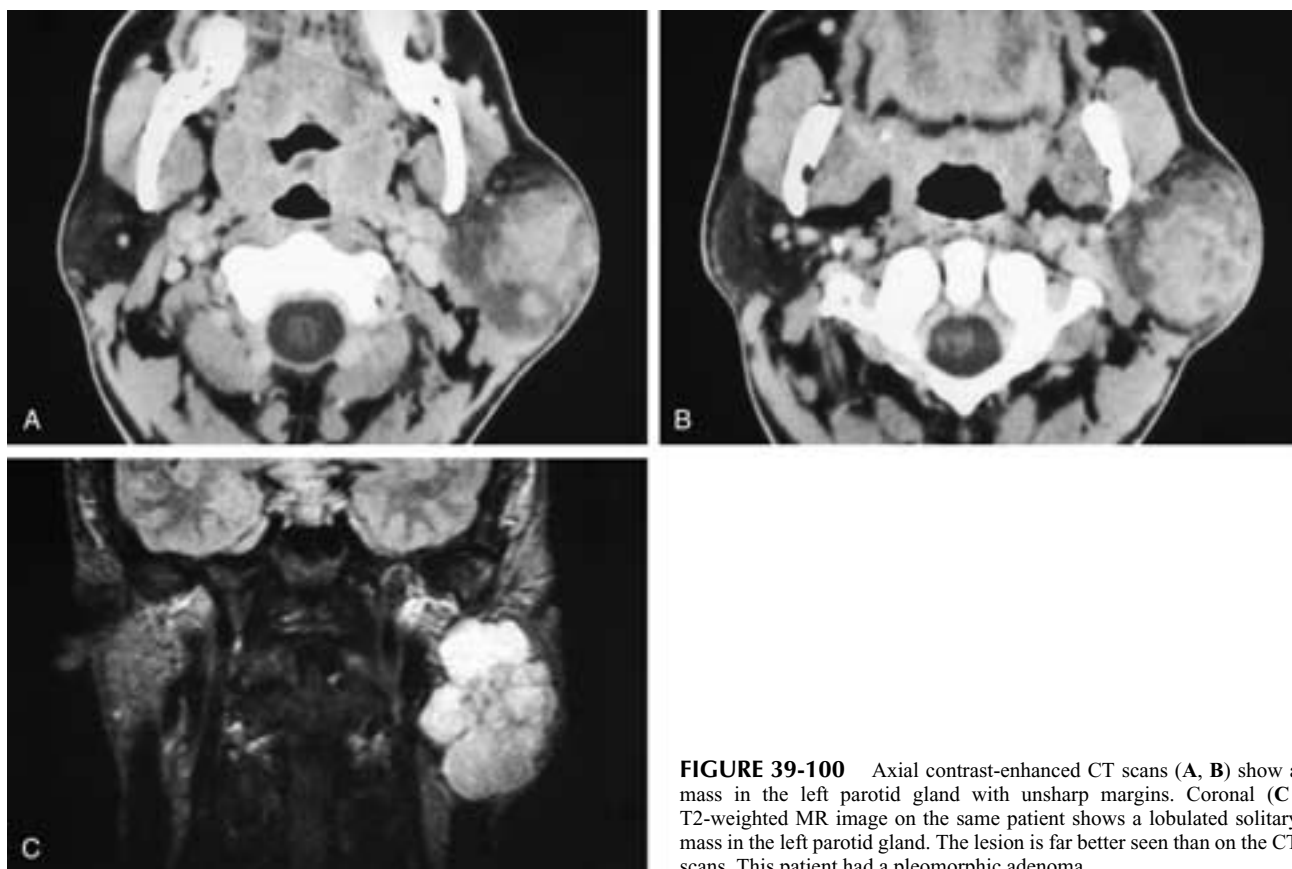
Axial contrast-enhanced CT scans (A, B) show a mass in the left parotid gland with unsharp margins. Coronal (C) T2-weighted MR image on the same patient shows a lobulated solitary mass in the left parotid gland. The lesion is far better seen than on the CT scans. This patient had a pleomorphic adenoma.
